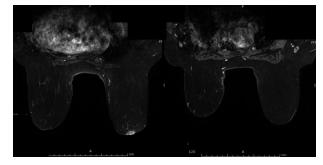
MRI shows the tumor localized at the right nipple and a second large metastases at the right axilla.
